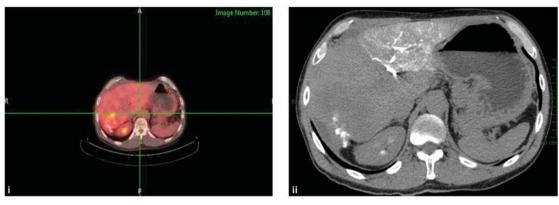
Imaging after four treatments of yttrium-90 microspheres and 12 cycles of FOLFOX-6. (i) PET scan imaging; (ii) CT angiogram.
